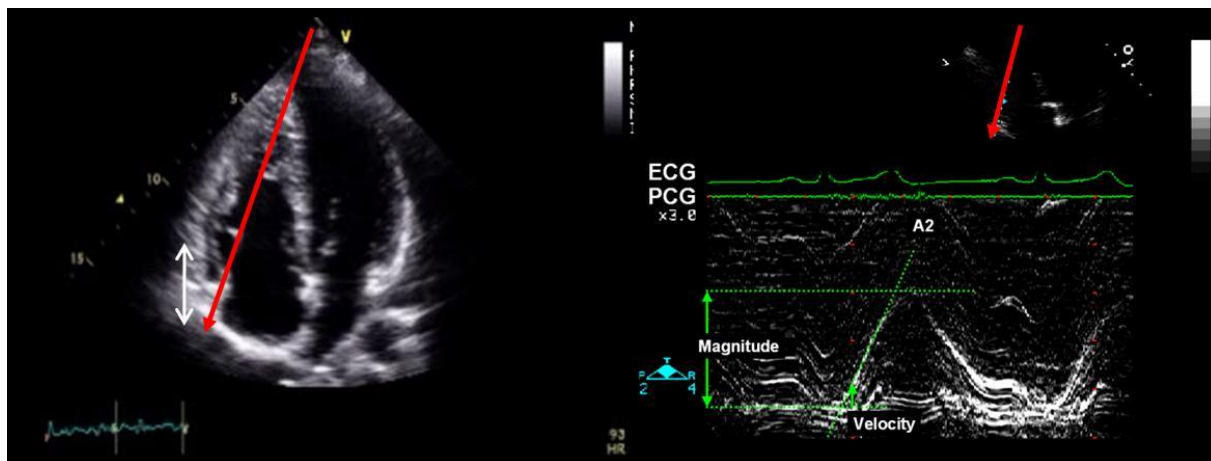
Estimation of RV contractility. On the left in an apical four-chamber view, the movement of the insertion of the tricuspid valve at the tricuspid annulus is shown (white arrow). In order to measure this, M-mode (red arrow) is placed across the tricuspid annulus. The resulting M-mode (on the right) shows the three components of TAPSE (see text for details)
